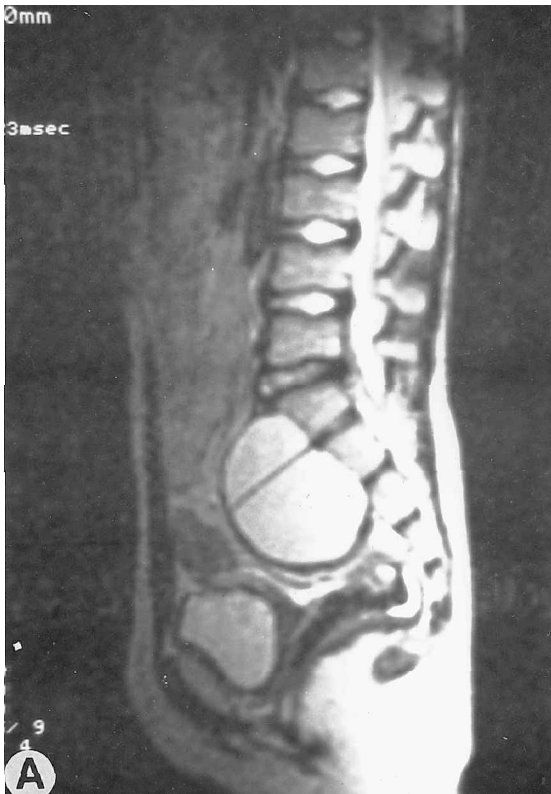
Unenhanced sagittal and coronal magnetic resonance imaging scans show a presacrally located cystic lesion (case 8). The lesion appeared hypointense on (A) T1-weighted and on (B) T2-weighted images.
